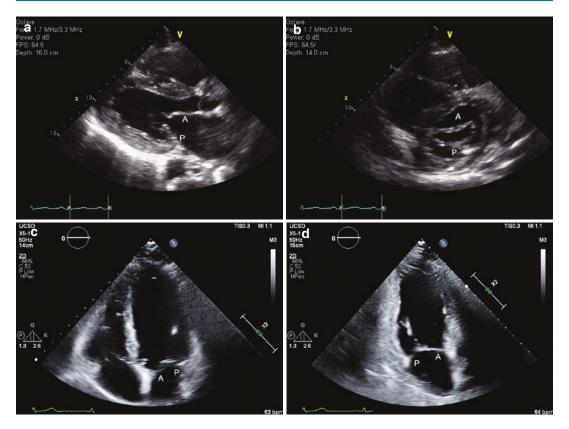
Transthoracic echocardiography (TTE) imaging of the mitral valve apparatus. (a) PLAX view. (b) PSAX view. (c) A4C view. (d) Apical two-chamber (A2C) view. *A* anterior leaflet, *P* posterior leaflet
